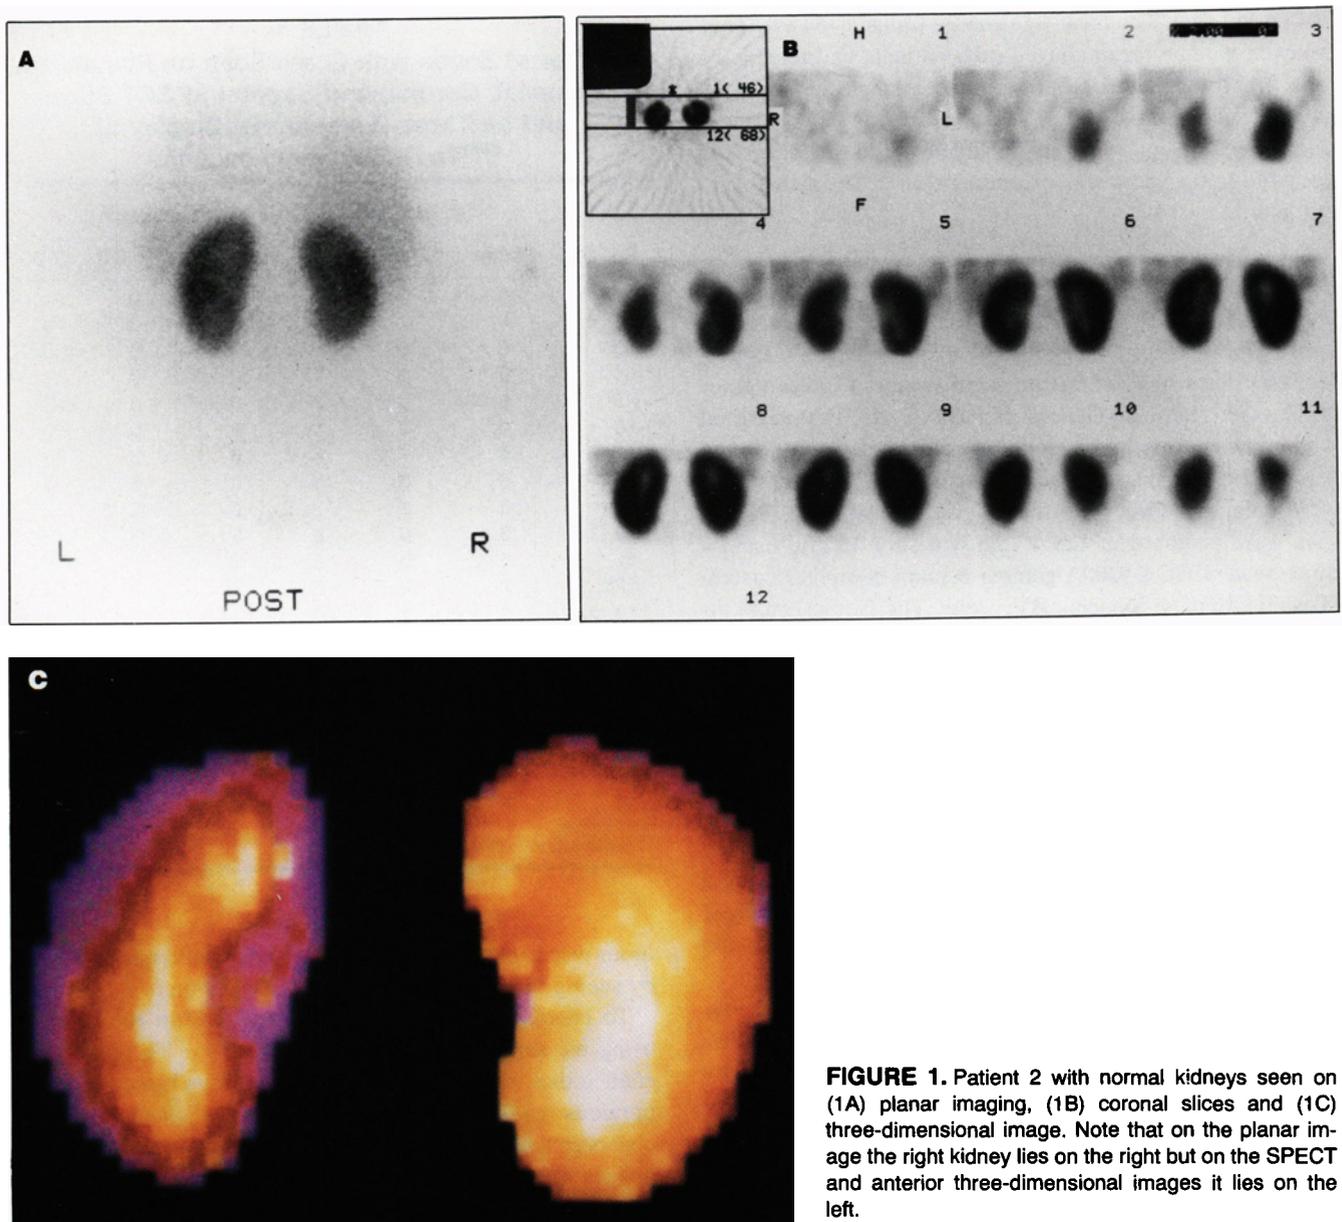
Patient 2 with normal kidneys seen on (1A) planar imaging, (1B) coronal slices and (1C) three-dimensional image. Note that on the planar image the right kidney lies on the right but on the SPECT and anterior three-dimensional images it lies on the left.
